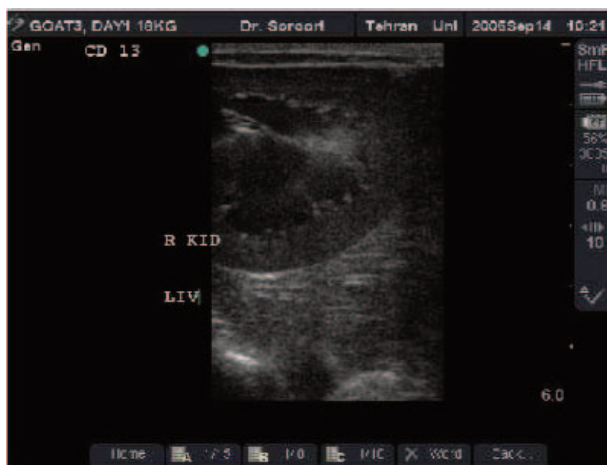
Ultrasonogram of the right kidney and liver. Transducer was placed caudal to the 13th rib. Liver texture seems slightly more echogenic than the renal cortex. LIV: Liver; R KID: right kidney.
